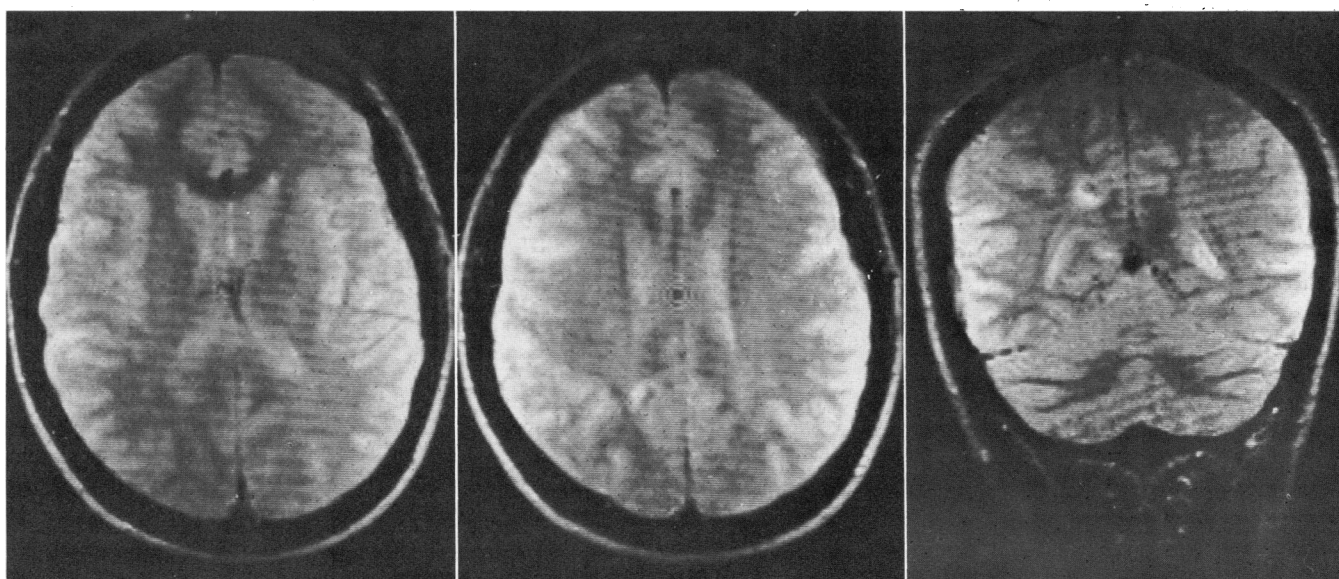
Patient 1. Follow-up magnetic resonance images three weeks after beginning therapy with praziquantel. There has been pronounced resolution of the edematous regions within the cerebral hemispheres. The central low density (right and middle) is a machine artifact and not a lesion.
